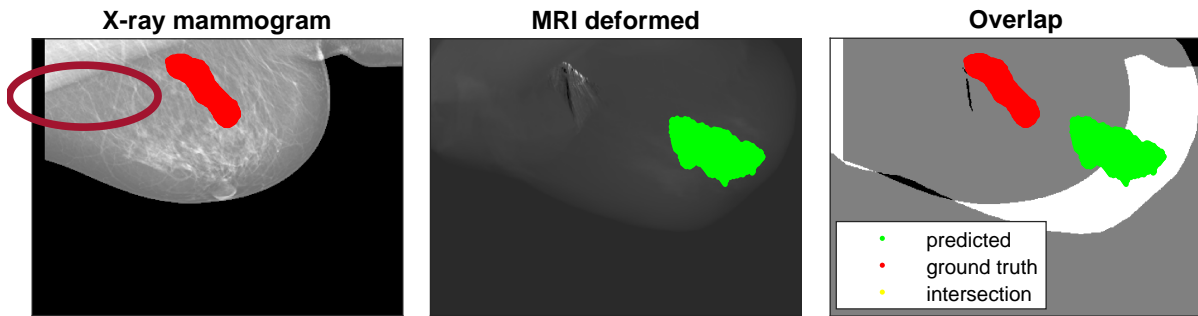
An example of a bad registration between MRI and X-ray mammography (Patient ID 31): original X-ray mammography and its problem of a rotation angle of muscle area (see red circle) (first), synthetic X-ray created from the biomechanical model based registration and its problem of an artifact in the image because of inaccurate segmentation (second). Overlap of the two images (third). The predicted lesion that has been annotated by radiologists in the original X-ray (red) and projected tracked annotation of the MRI into the synthetic X-ray (green).
